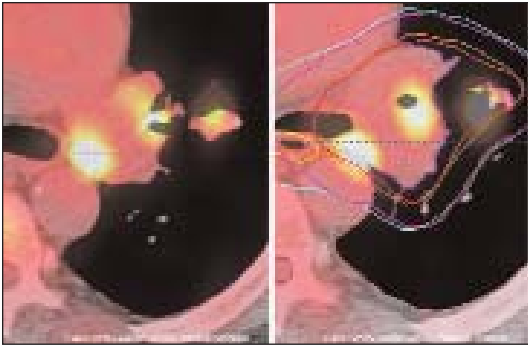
Effect of motion on PET/CT imaging. Although PET may cause an increase in GTV, this information may provide a valuable estimation of organ internal motion. A: End of inspiration. B: End of expiration.
